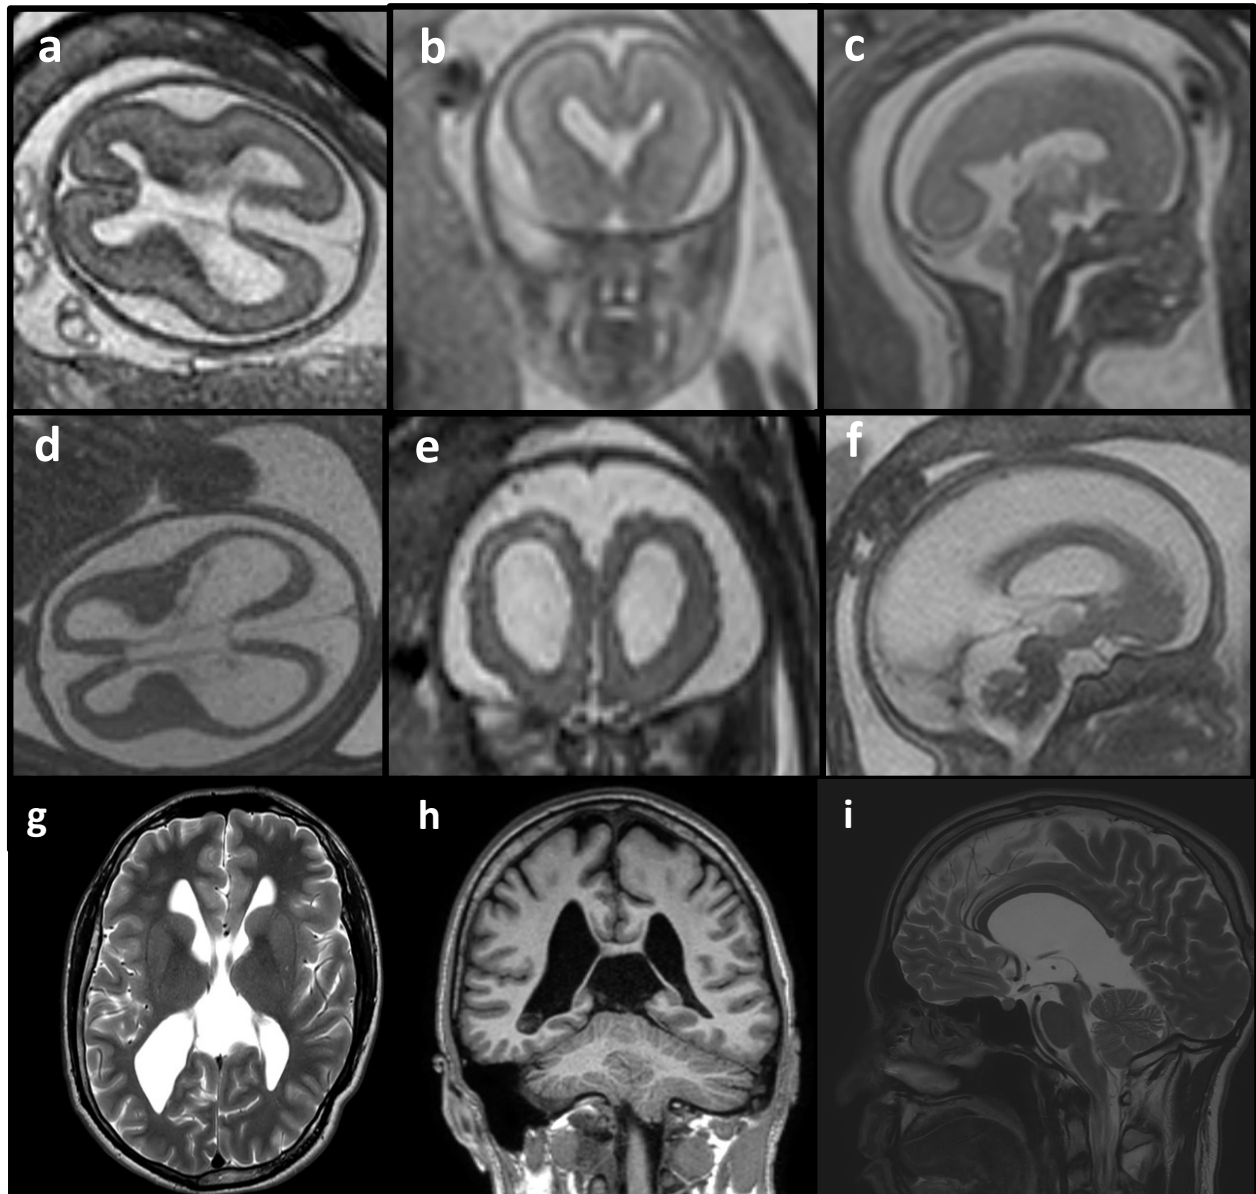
MRI findings in the fetus at 22 GW (a,b,c) 25 GW (d,e,f) and in the father (g,h,i).
